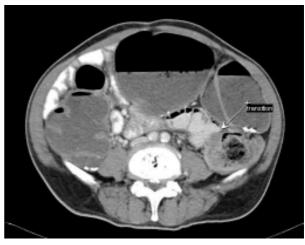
Axial view CT reveals the transitional zone at sigmoid colon (arrow), which shows intermediate change of caliber without any cause of mechanical obstruction.
